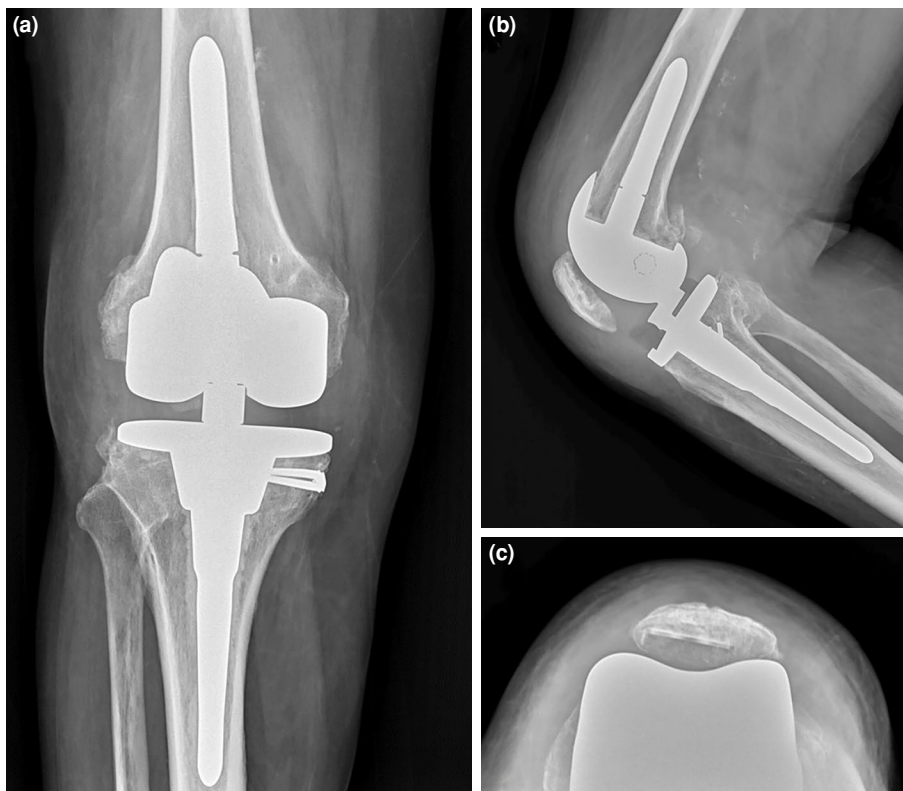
Postoperative radiograph of right knee (a) anteroposterior view (b) lateral view (c) merchant view showing well seated implant and adequate patellofemoral tracking after total knee arthroplasty.
